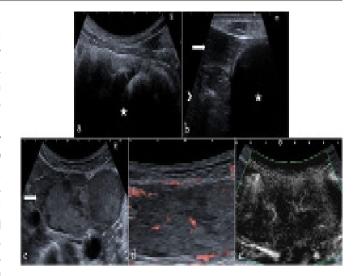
B mode and SMI Doppler US images: Liver (arrow), stomach (arrowhead), lesion of gossypiboma (star) (a,b), lobule contoured solid mass (NET) lesion with vascularity on SMI and monochrome image (c,d,e).
